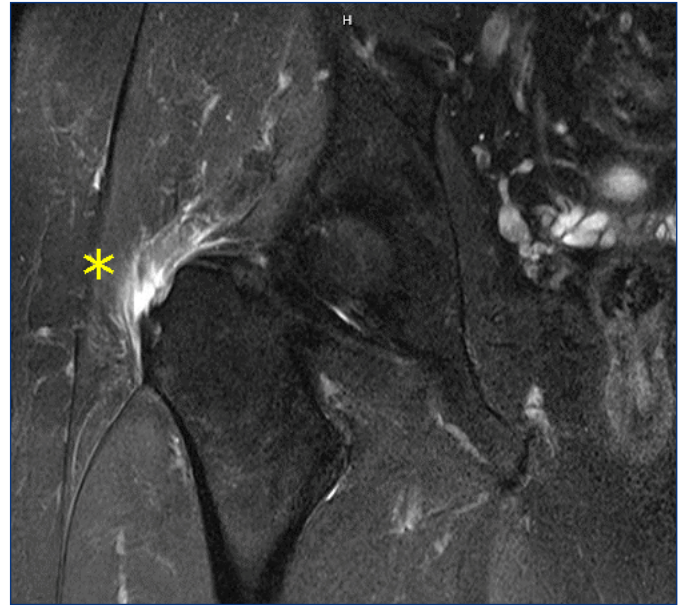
A T2 fat-saturated coronal MRI cut of the patient's right hip with the patient supine with bilateral legs internally rotated 15 degrees. This shows a full thickness partial width tear of the gluteus medius tendon off of the lateral facet of the greater trochanter with retraction (yellow asterisk)
